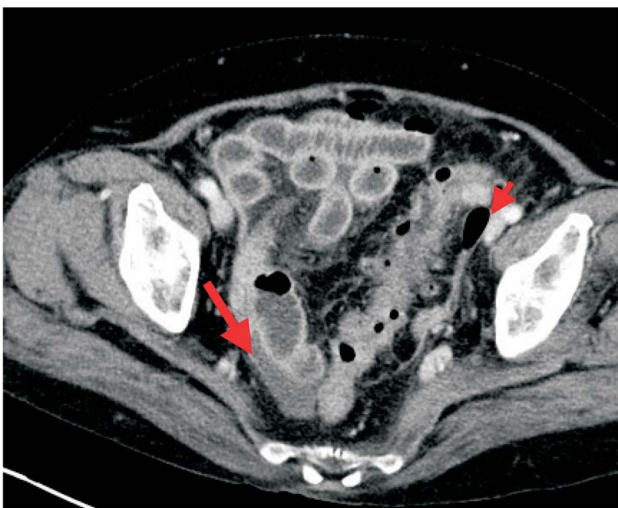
An axial view of a abdominal computed tomography showed Hinchey stage III diverticulitis with generalized purulent peritonitis (big arrow) and perforation (small arrow).
